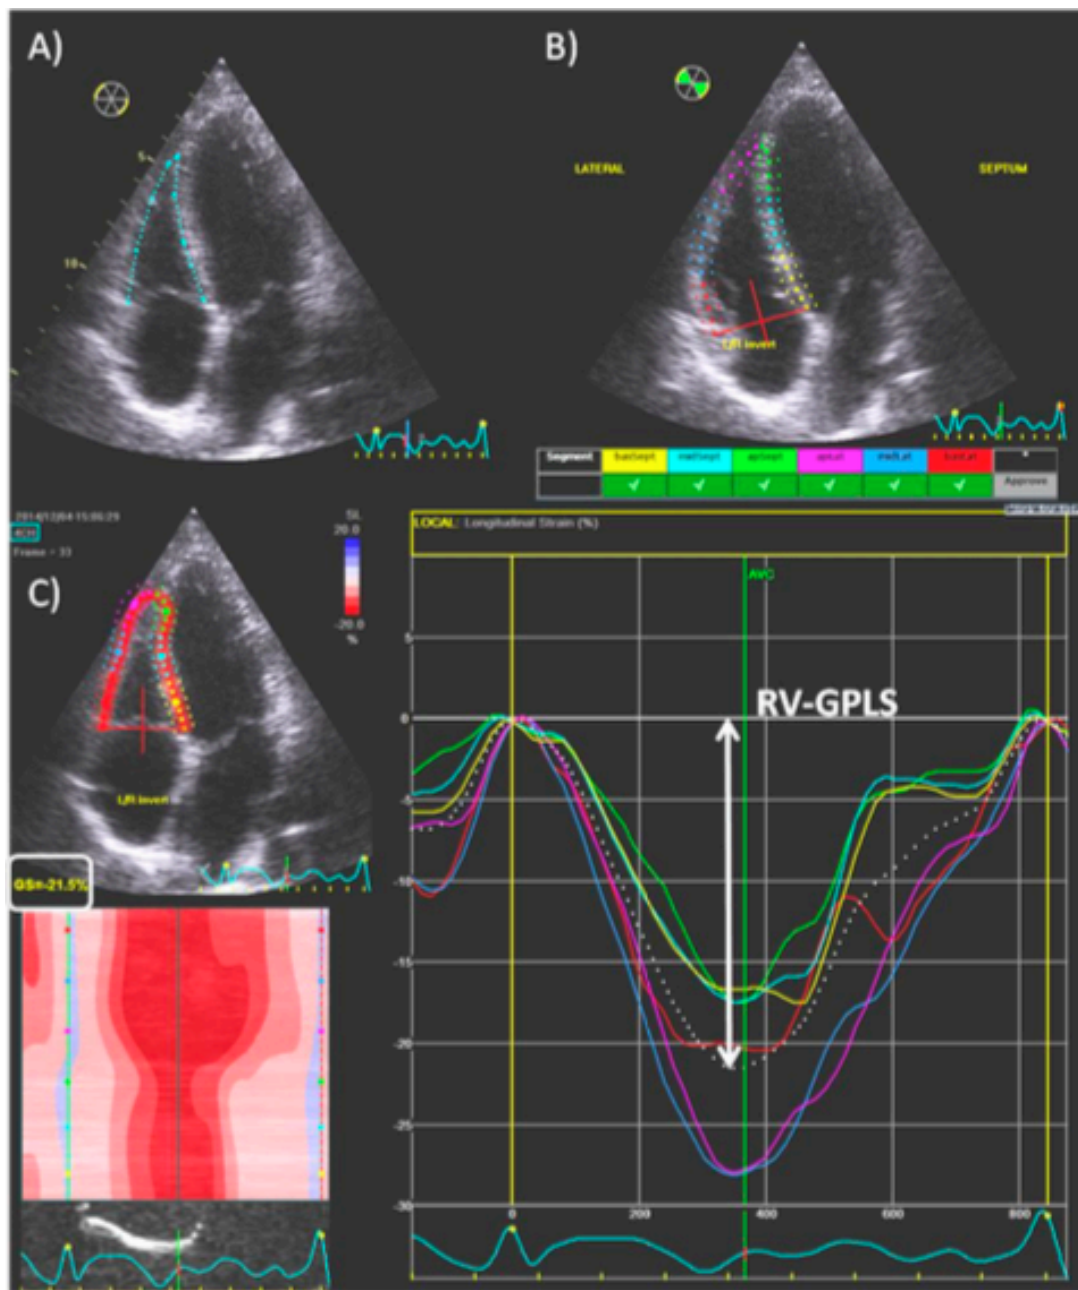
Speckle tracked echocardiography strain calculation
